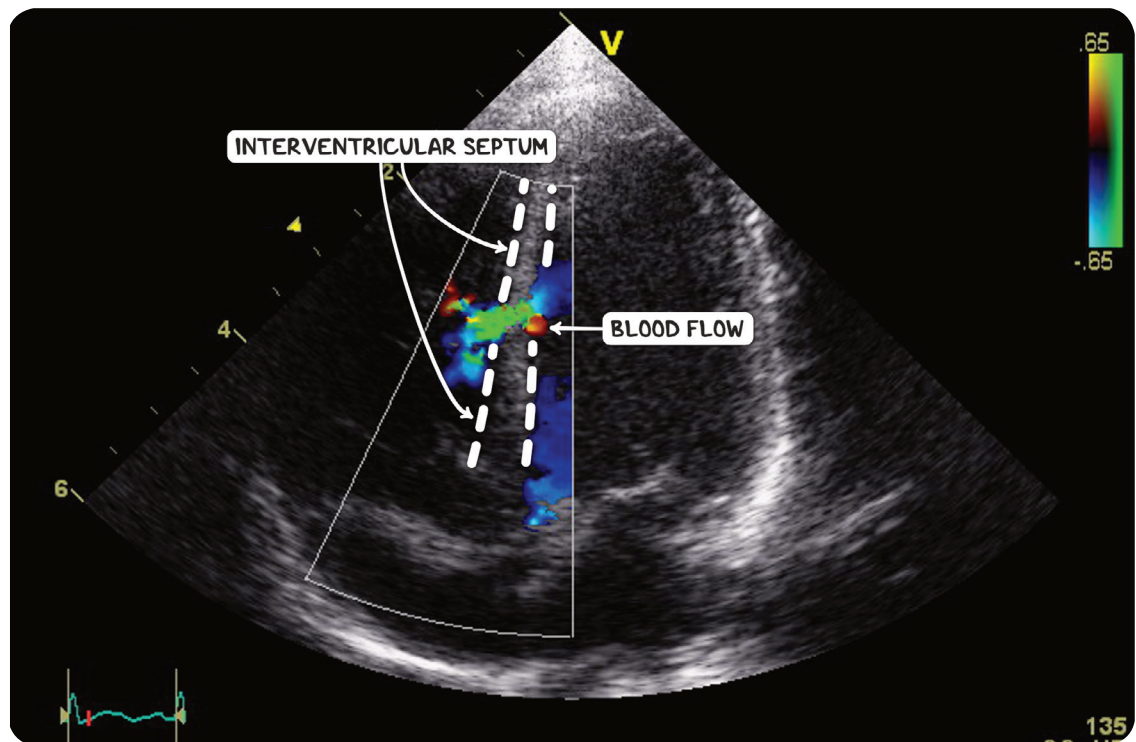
Doppler ultrasound scan demonstrating flow of blood across the interventricular septum in a VSD.
